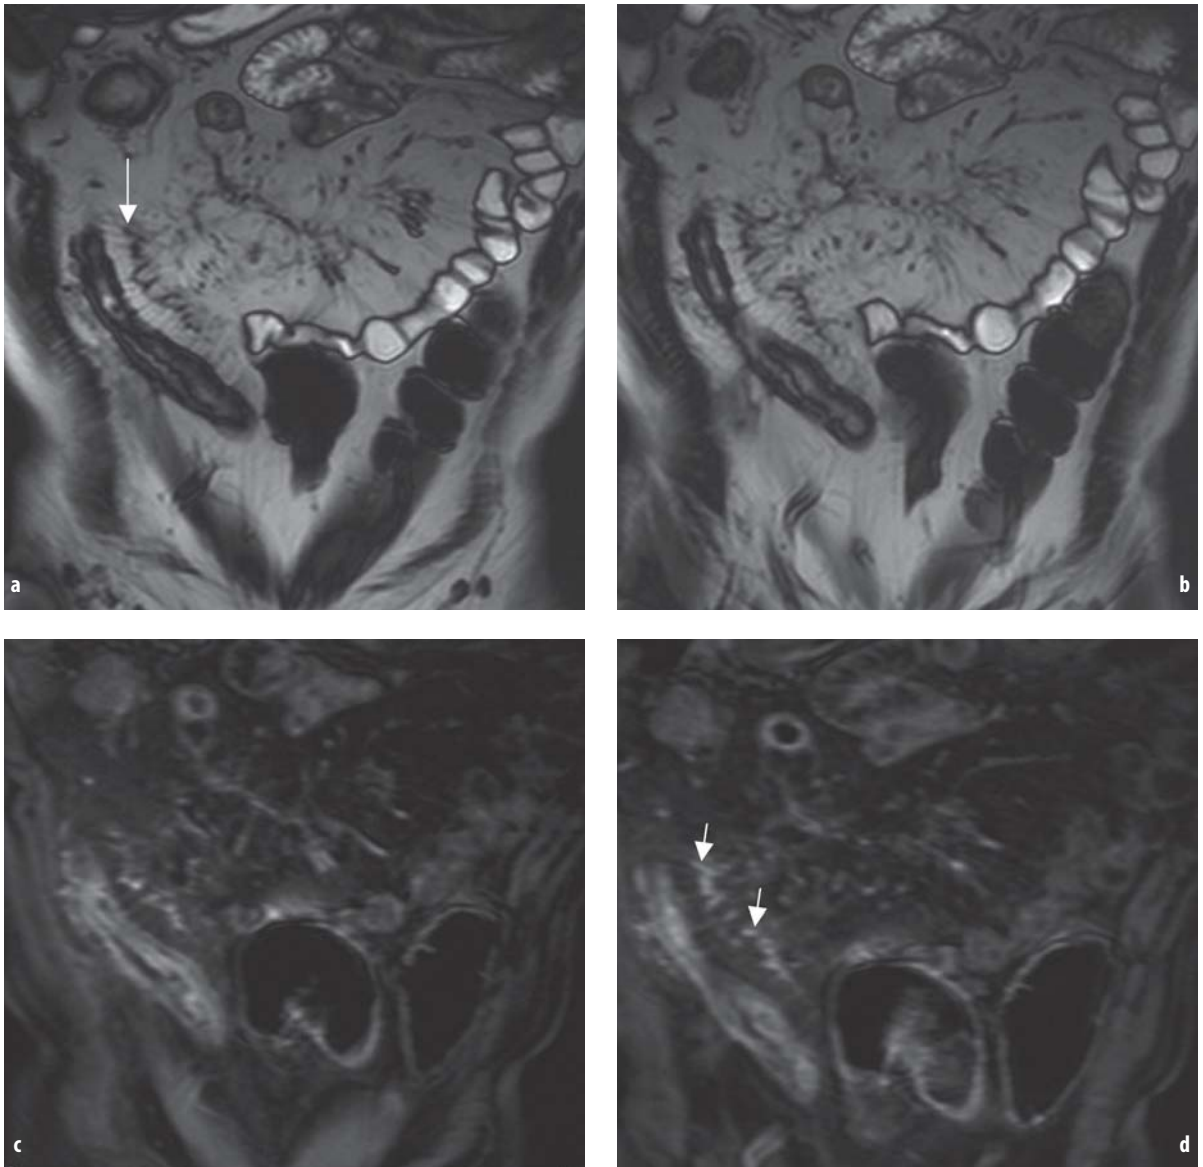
A 27-year-old man with active Crohn's disease. a, b On coronal true FISP images Mesenteric vessels (vasa resta) are clearly detectable depicting the so-called "comb sign" which corresponds to hypertrophied mesenteric vascularisation perpendicular to the axis of the affected bowel loop (*arrow*). c, d Contrast enhanced T1-weighted gradient echo images, confirm disease activity (*arrows*)
